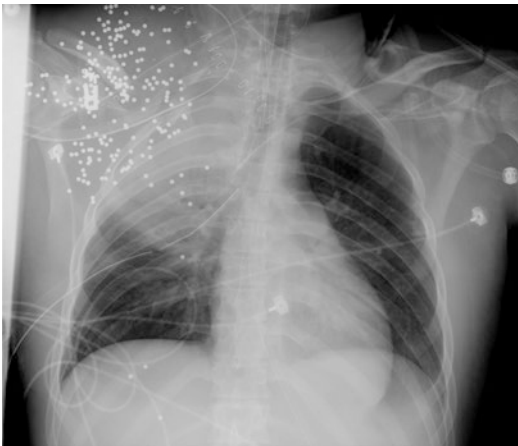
Scapula and Clavicle Fractures. Chest x-ray of a 24-year-old man who sustained a gunshot wound to the right neck for which he sustained multiple injuries including disruption of the subclavian artery and fractures of the scapular body, clavicle, transverse process of C7 and first and second ribs. He underwent free functioning muscle transfer for treatment of the concurrent brachial plexus injury
